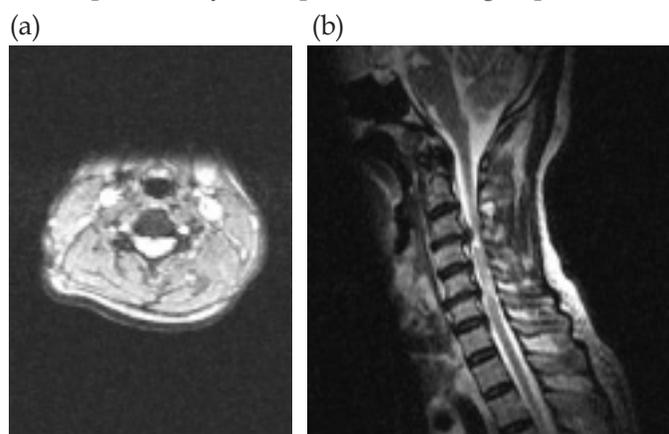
(a) side view and (b) cross-sectional view from MRI (T2 weighted) showing spinal cord compression at the C3/C4 and C5/C6 levels.
